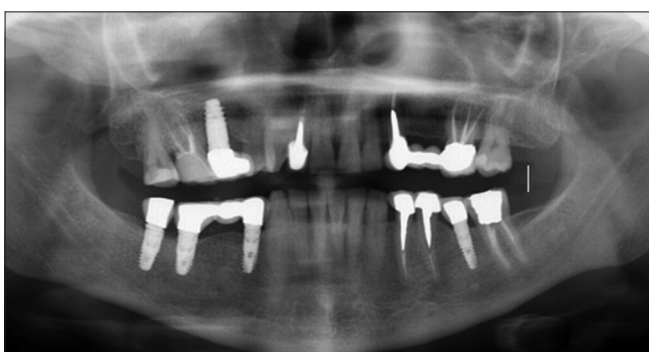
Panoramic radiograph with 6-month follow-up
